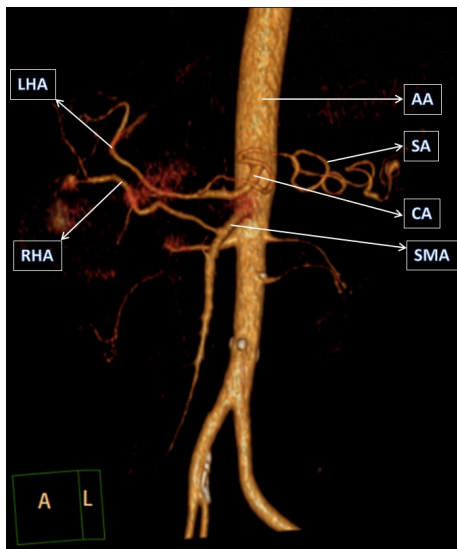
3D volume rendered CT image showing abdominal aorta and its anterior visceral branches [AA- abdominal aorta , SA- splenic artery, CA- coeliac artery , SMA- superior mesenteric artery , LHA- left hepatic artery, RHA- right hepatic artery]
